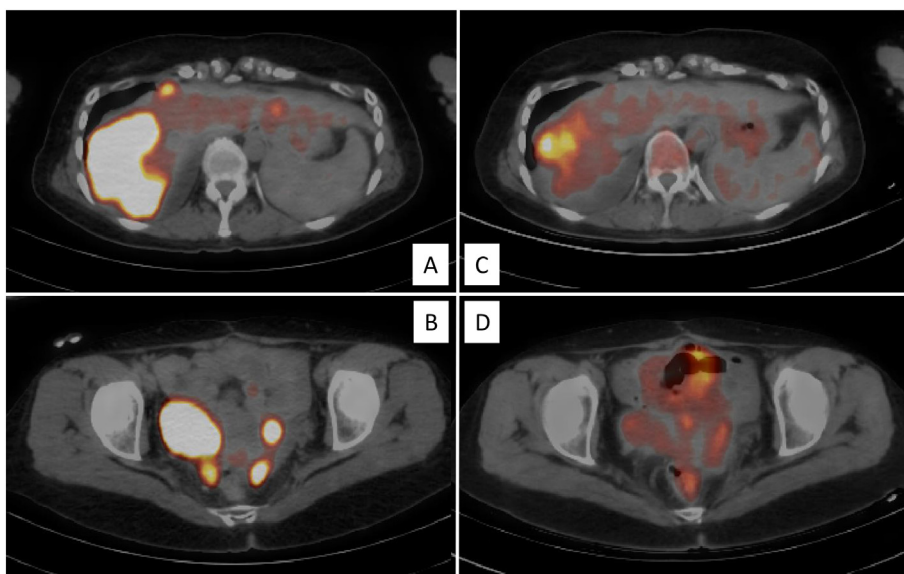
A: 18F-fluoro-deoxyglucose positron emission tomography-computed tomography images before (A, C) and 1 month after (B, D) the initiation of pazopanib treatment. A: Before treatment, the largest tumor, which was under the right diaphragm, had an SUVmax of 10.53 and a diameter of 7 cm. B: After treatment, this tumor shrank to 5 cm, and the SUVmax decreased to 5.41. C: The image shows the tumor in the pelvis near the uterus and in the Douglas pouch before treatment. D: After treatment, this tumor had decreased in size.
